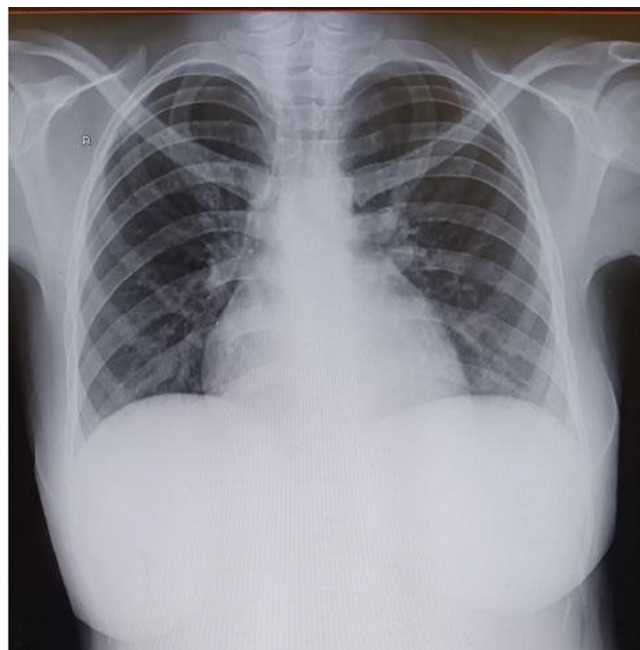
Posteroanterior chest X-ray of the patient, which appeared grossly normal.
